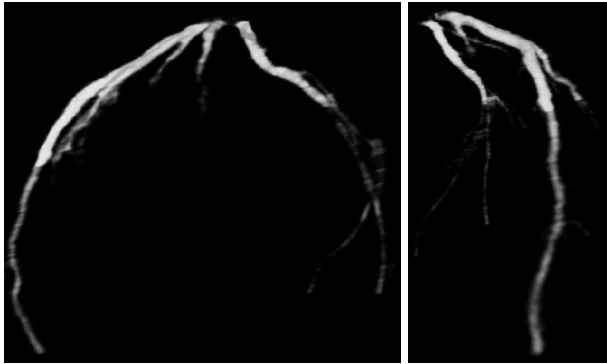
Left coronary tree without lesions. Video renderings are available at www.die.upm.es/im/videos/CT/.
